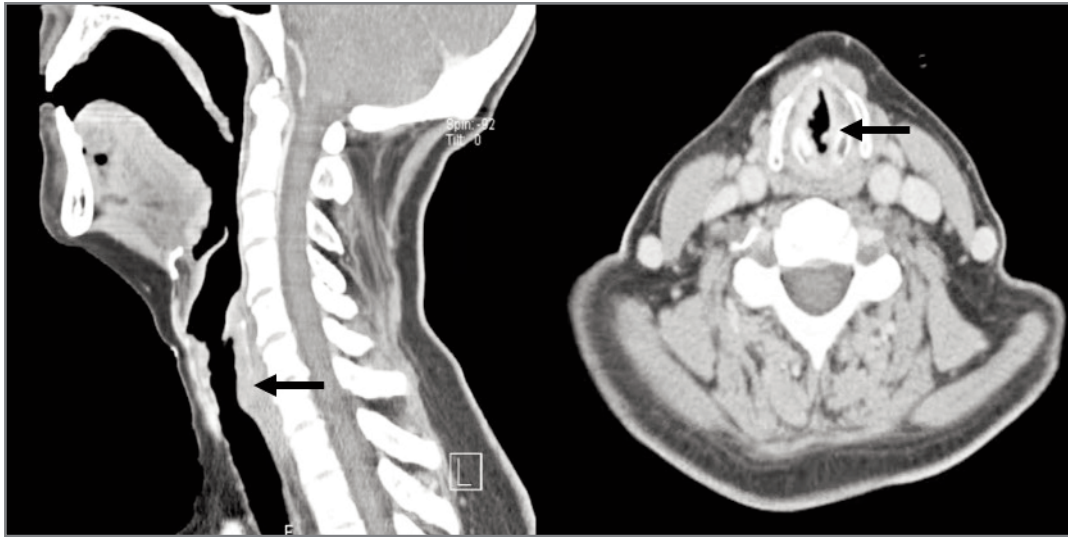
Neck computed tomography showing reduced air column diameter due to soft tissue thickening at infraglottic stage
